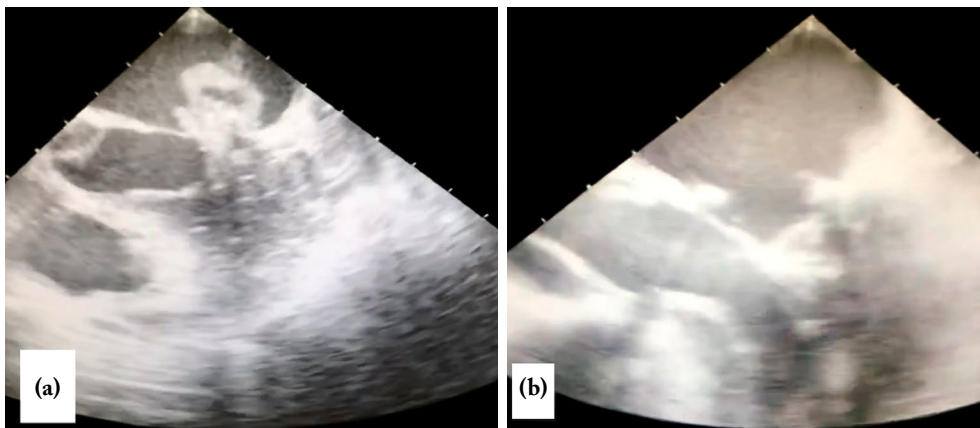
(a) Preoperative transesophageal echocardiography. Arrows indicate multiple large vegetations on the posterior leaflet. (b) Postoperative transesophageal echocardiography. Both mitral leaflets' movements and coaptation are good. Arrows indicate good leaflet coaptation and prosthetic ring materials.
